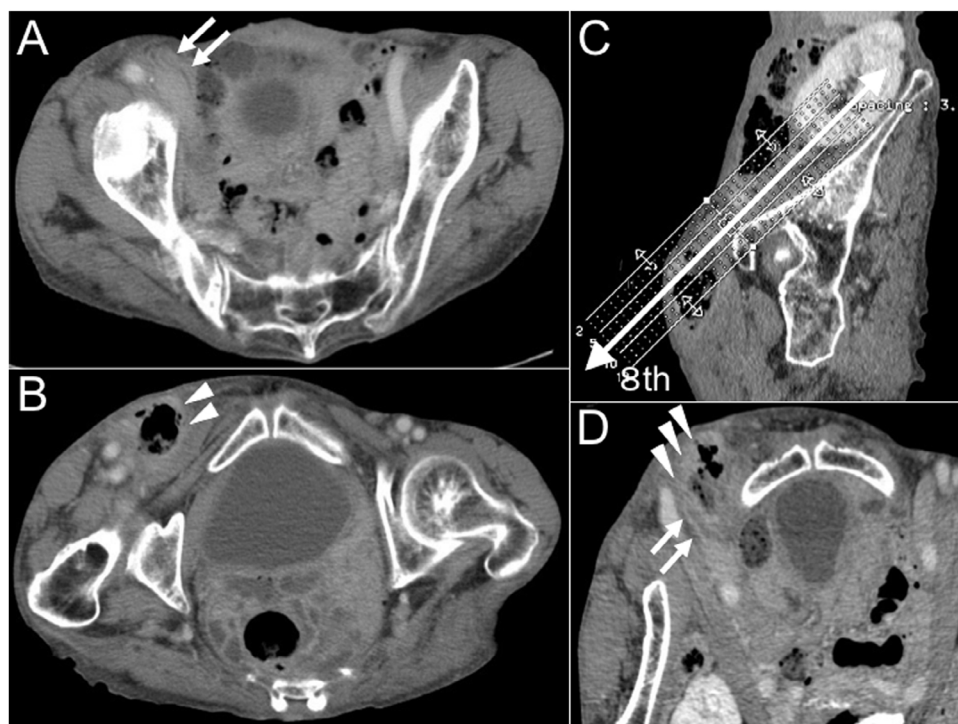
Computed tomography image.
